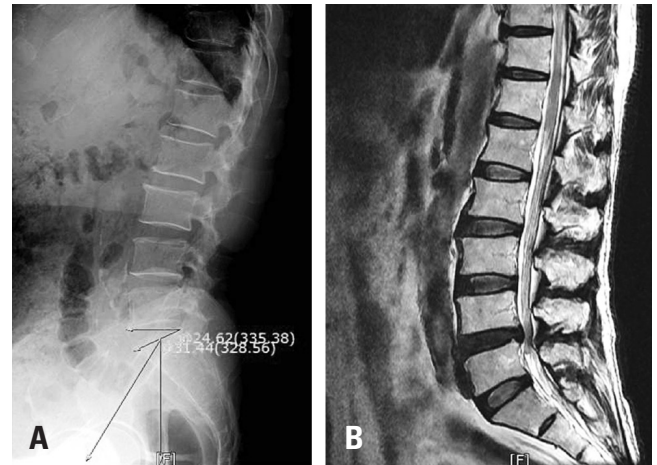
Radiography of a 67-year-old male with high pelvic tilt. (A) Upright lateral X-ray. (B) T2 sagittal image of lumbar magnetic resonance imaging.
